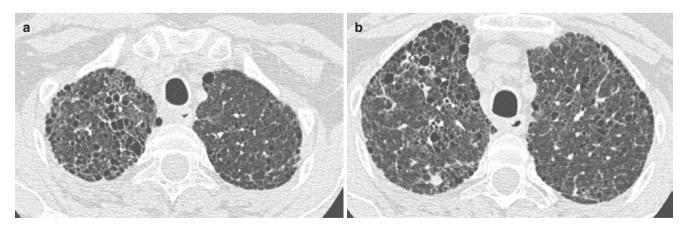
Honeycombing versus cystic lung disease. (a, b) Axial CT images show subpleural honeycombing and centrally located small cysts in the same patient
